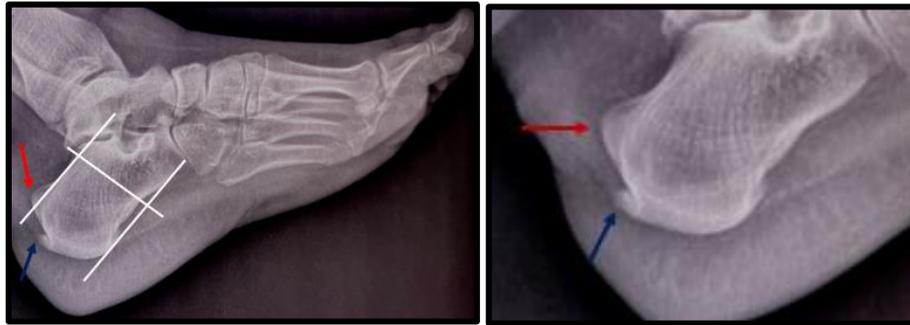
Lateral radiograph of the left foot showing a prominent posterosuperior osseous calcaneal protuberance (blue arrow), and ossification in the thickened Achilles tendon (red arrow)
